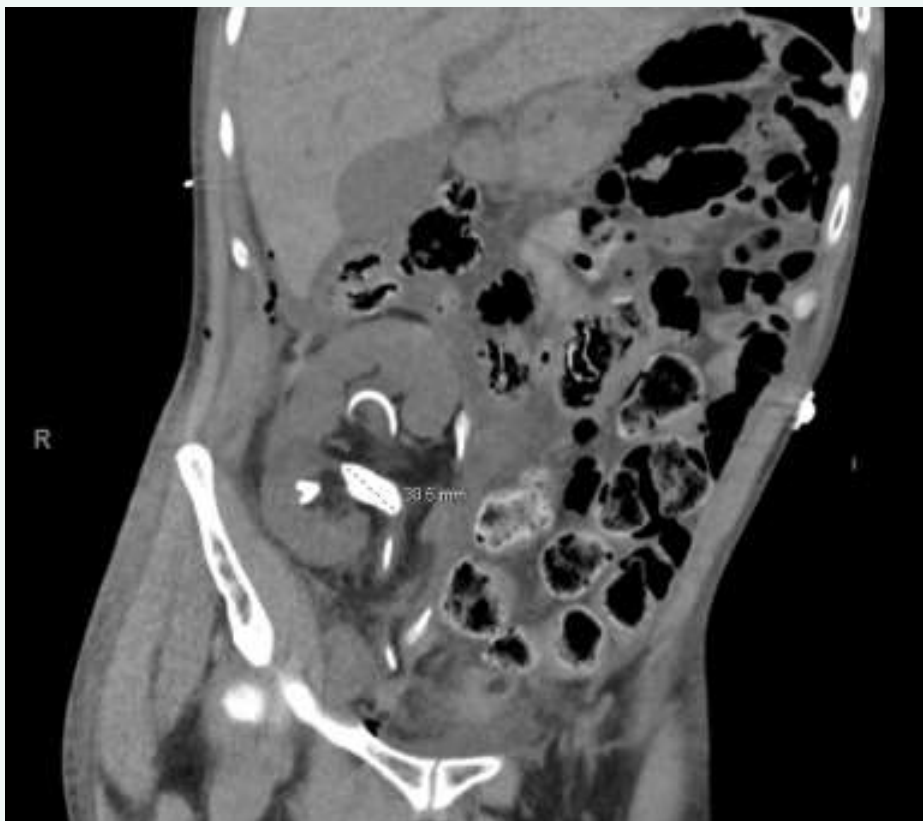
CT scan coronal view post kidney transplant depicting a large donor-gifted calculus with moderate lower calyceal hydronephrosis and adequate drainage of upper pole by double-J ureteral stent
